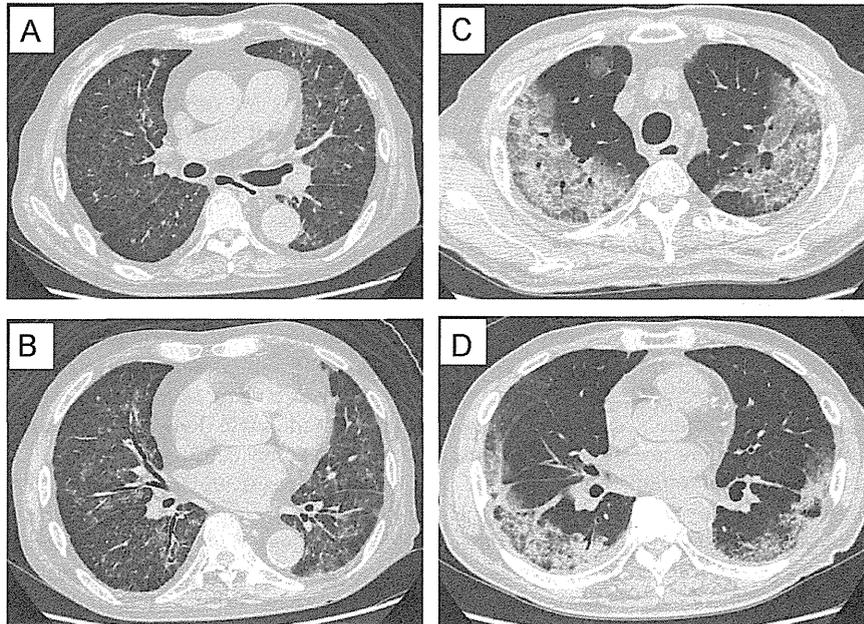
Chest CT imaging. Case 1: A set of chest CT images showing bilateral ground-glass opacities with interlobular thickness. (A) Subcarina level, (B) lower lobe level. Case 2: A set of chest CT images showing peripheral predominant ground-glass opacity and consolidation. (C) Upper lobe level, (D) lower lobe level. CT: computed tomography.
